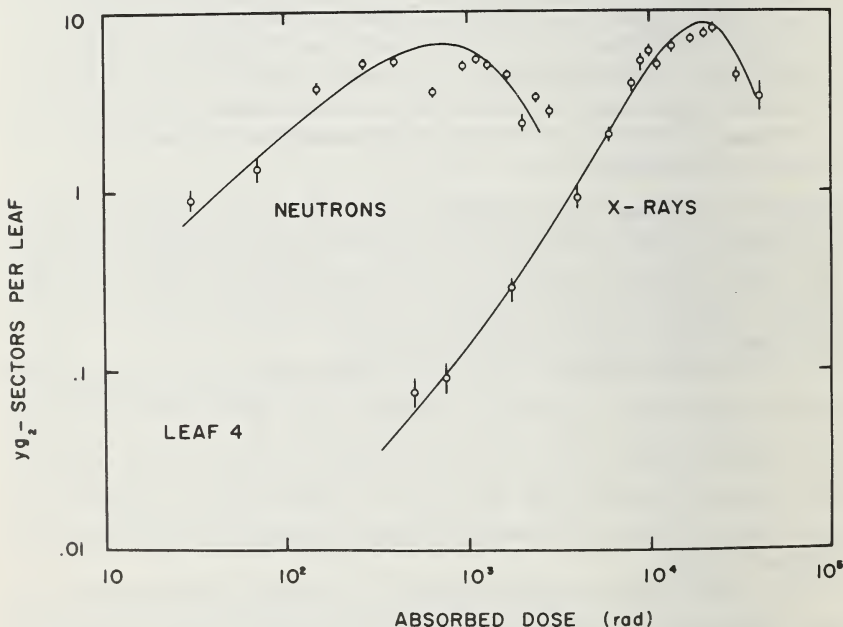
Mean numbers of yg_2 sectors in maize leaf 4 as a function of x-ray and neutron dose (logarithmic plot). The vertical bars indicate standard deviations due to Poissonian fluctuations of the observed events. (From Smith *et al.*, 1974).
